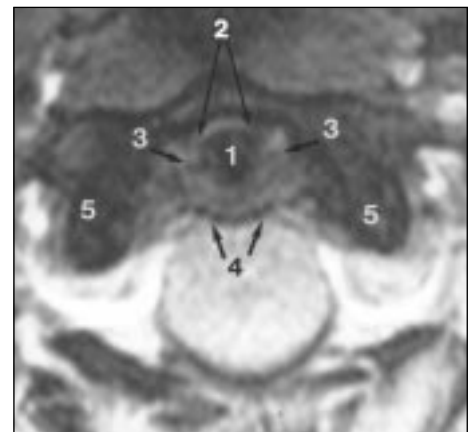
Normal anatomy in 38-year-old man. Axial gradient-echo or fast low-angle shot MR image (TR/TE, 420/18; flip angle, 30°) obtained on 1.0-T MR scanner shows dens (1), presumed anterior atlantodental ligaments (2), alar ligaments (3), transverse ligament (4), and lateral masses of C1 (5).
